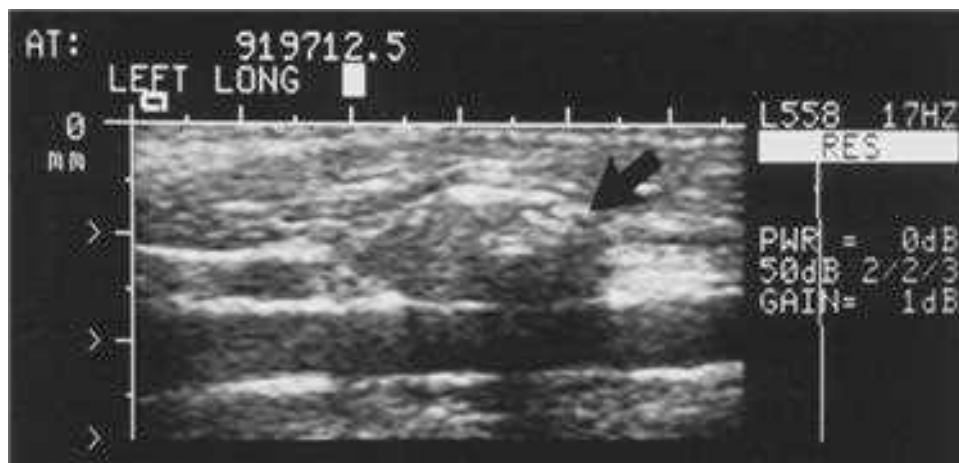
Thyroid ultrasound showing a lymph node (arrow) along the carotid artery.
